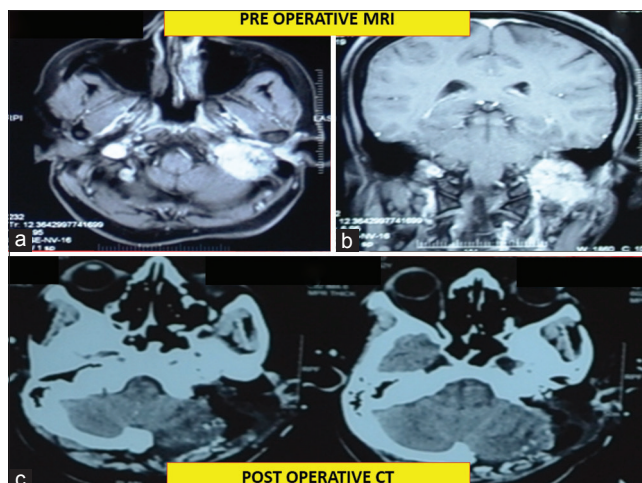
Preoperative and postoperative images of patient 3: (a and b) preoperative contrast-enhanced axial and coronal magnetic resonance imaging images. (c) Postoperative computed tomography shows near-total excision
